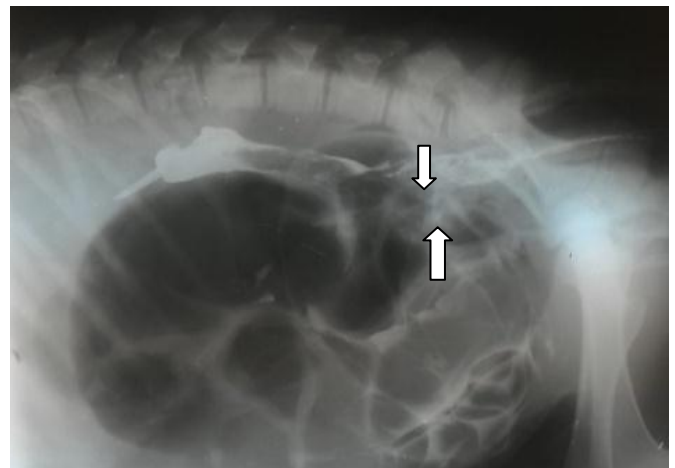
Contrast radiograph revealing presence of stenosis at the colon.
